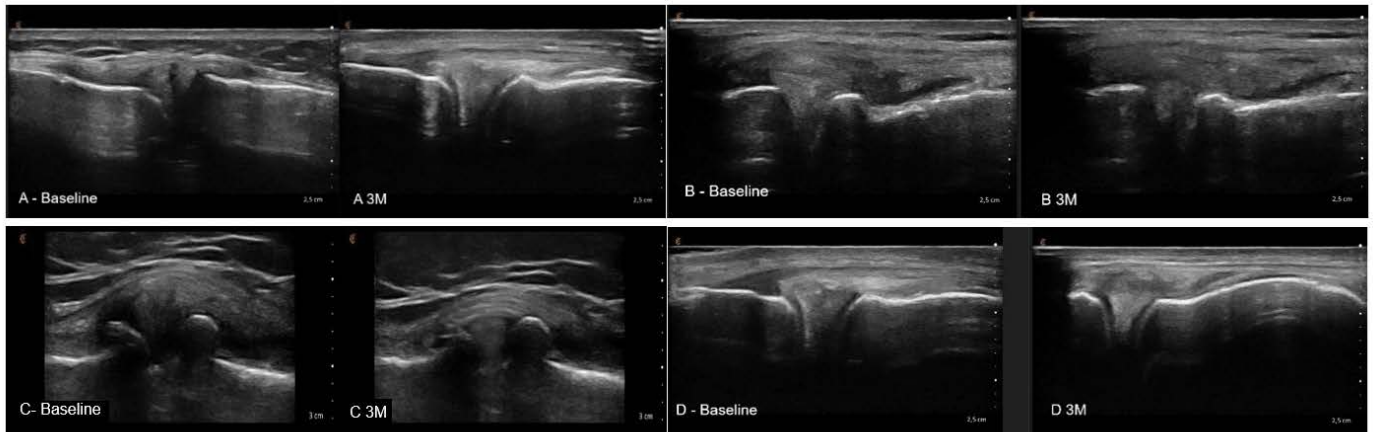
Sonographic pictures of treated meniscal injuries, before, and 3 Months after the PRF/HA and ALB-PRF treatment. A, A clear central rupture in the outer portion of the meniscus completely healed and a reduction of 5 mm extrusion. B, Mean change of meniscal extrusion of 4 mm. C, Osteoarthritic knee with typical osteophytes and a clear 6mm extrusion of meniscus in the before picture, a near complete reduction after 3 months. D, Medial meniscal extrusion of 3,5 mm above the tibial margin reduced to a normal position after 3 months.
